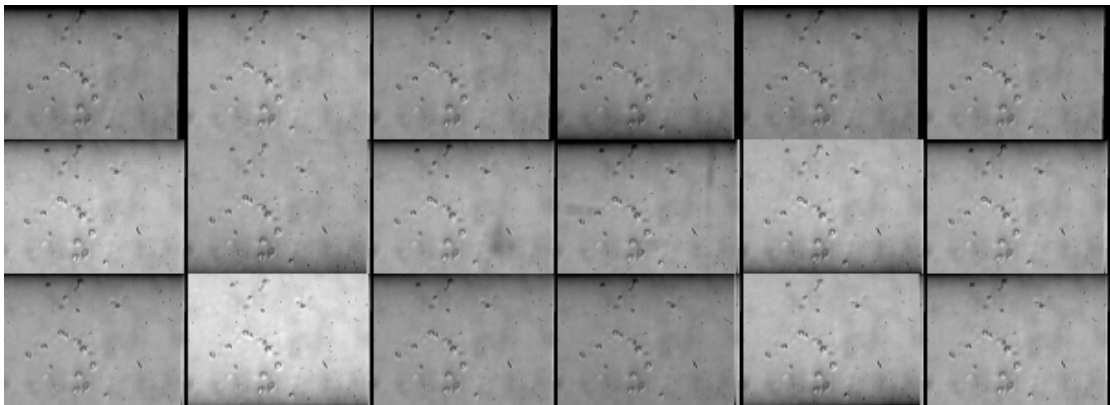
PLA microbubbles at rest with no ultrasound excitation.
